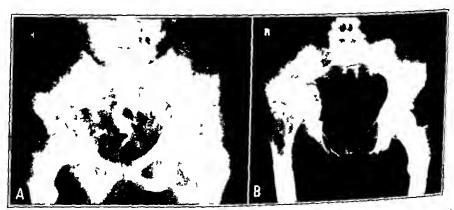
Solitary myeloma with the pathologic characteristics of plasmacytoma A, melting away of a portion of the acetabulum and ilium. The patient was given roentgen therapy B, result forty-nine months later. There are evidence of healing and intrapelvic protrusion of the head of the femur. The patient is living and well fifty-two months after the institution of treatment.
